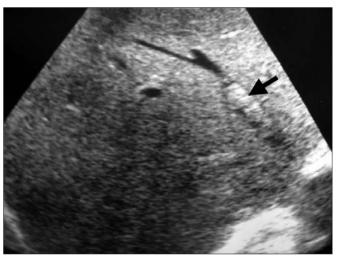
Abdominal ultrasonography examination demonstrates the right hepatic vein partially occluded by a tumoral thrombus (arrow).
